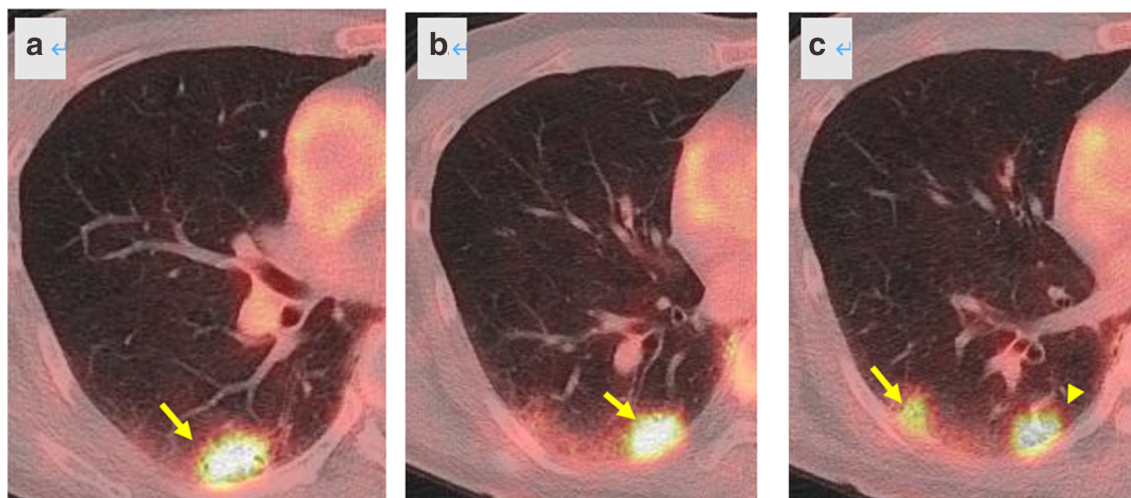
Positron emission tomography (PET) showing significant uptake in each nodule (arrows in each figure), with a standardized uptake value (SUV) of (a) 9.9 in the superior segment nodule; (b) 14.6 in the posterior basal segment nodule; and (c) 3.7 in the lateral basal segment nodule. The arrowhead indicates the tumor in (b) (posterior basal segment nodule).
